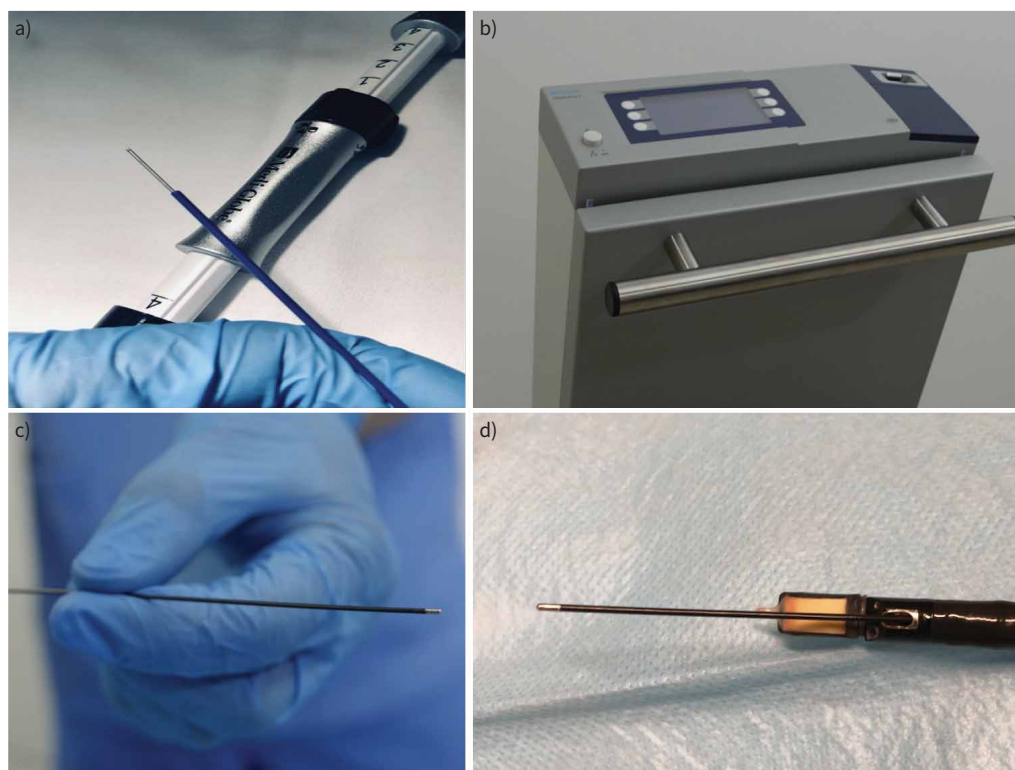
a) 22-G needle (SonoTip TopGain: three-point needle tip design with a crown cut). b) ERBECRYO 2 system. c) 1.1-mm cryoprobe (Erbecryo 20402-401). d) 1.1-mm cryoprobe through the working channel of the endobronchial ultrasound bronchoscope (EB19-J10U).
